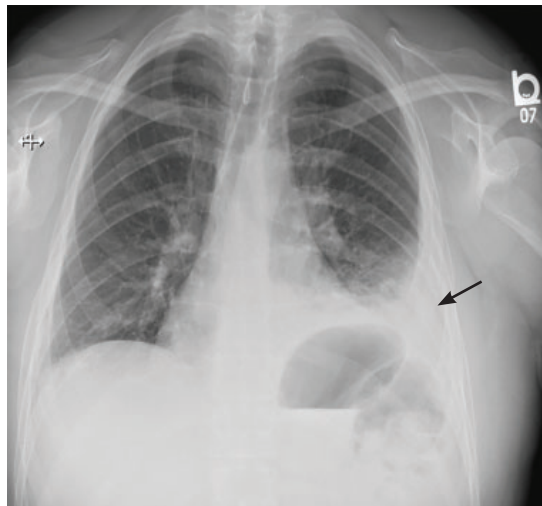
Chest radiography 5 days after the emergency department presentation showed development of a left-sided pleural effusion.
